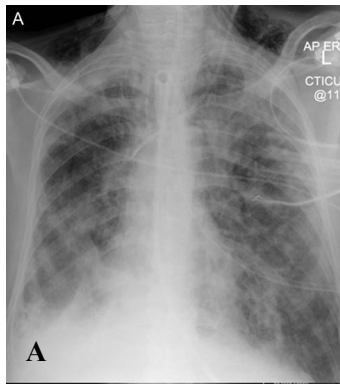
A: Chest radiograph of patient with ARDS shows bilateral infiltrates. There is bilateral consolidation and a right pleural effusion. B: Chest radiograph of the same patient shows persistent bilateral infiltrates after 7 days¹³²
